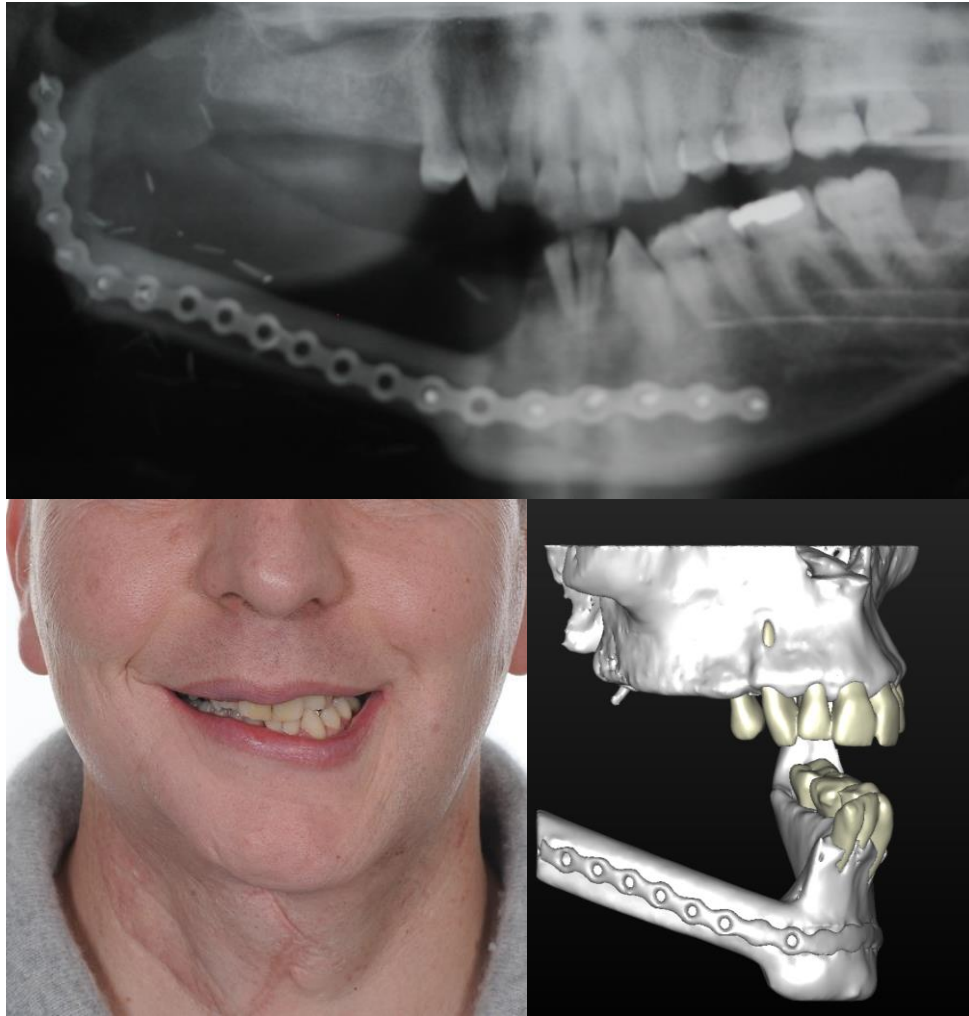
CT scan and OPT radiograph showing sectional mandibuloectomy and reconstruction with a single barrel fibula free flap – note the vertical discrepancy between the fibula bone and the remaining native mandible as the fibula bone is placed along the inferior border of the mandible to provide a good facial profile. Also notes the deep soft tissue overlying which is unfavourable for restoration and required surgical debulk at the time of implant placement.
